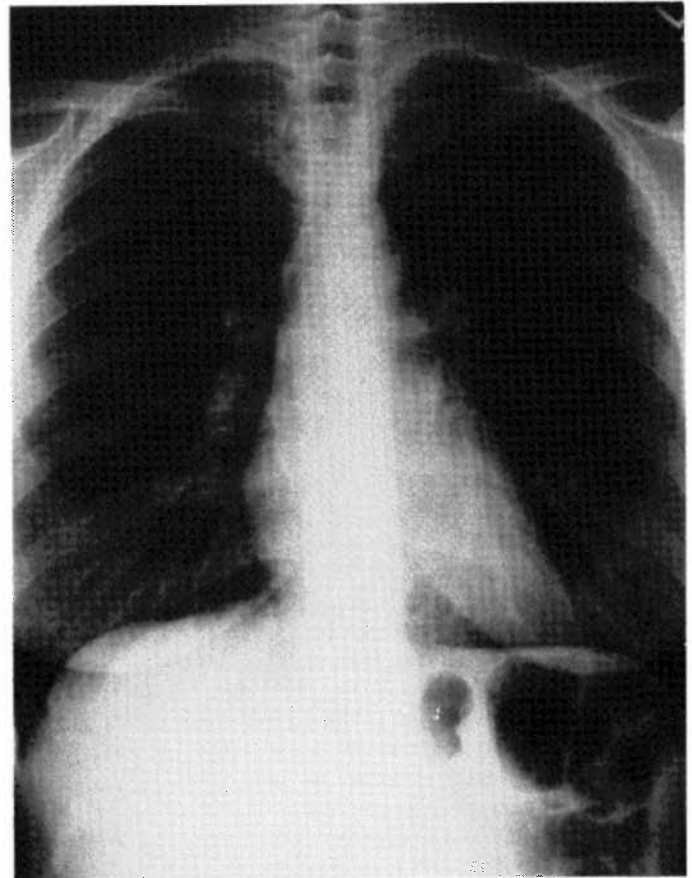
Normal baseline chest X-ray, 1988.
